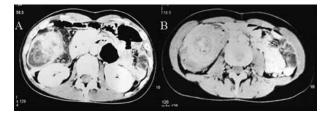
A. CT scan showing the cecal lymphoma and the intussusception. B. The pathognomonic unhomogenous "target" shaped soft tissue mass is shown.
